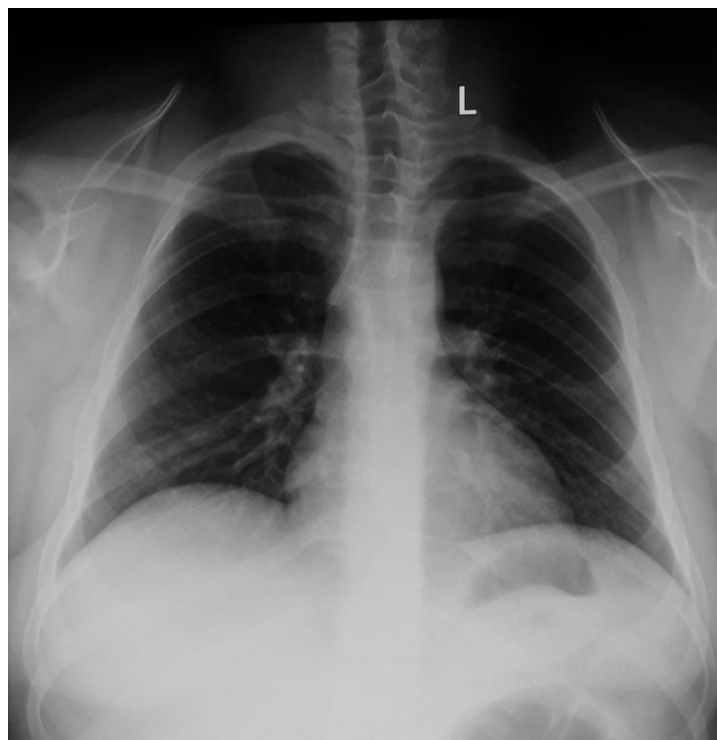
X-ray chest PA view after 48hrs showing B/L clear lung fields
